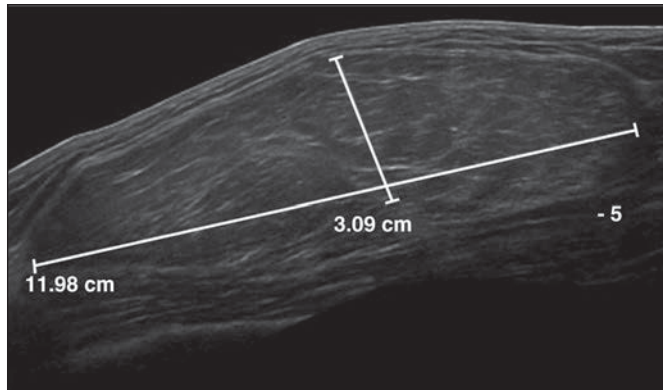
39-year-old man with lipoma of upper arm. Extended FOV gray-scale sonographic image shows 12-cm uniform, well-circumscribed, hypoechoic mass. Possibility of malignancy was suggested because of size. Excision revealed benign lipoma.
